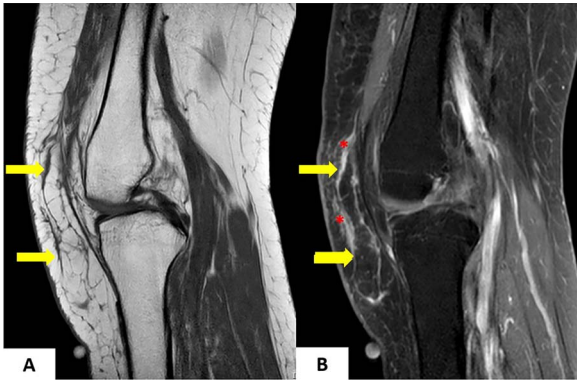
Sagittal T1-weighted (A) and post-Gd T1-weighted fat suppression (B) images show an encapsulated fatty lesion (arrow) at the anterolateral aspect of the knee. The lesion shows hyperintensity on the T1-weighted image and hypointensity on the post-Gd T1-weighted image with a few thin septal enhancements. No internal enhanced solid components are seen. Peripheral subcutaneous fat edema is also noted (asterisks).
